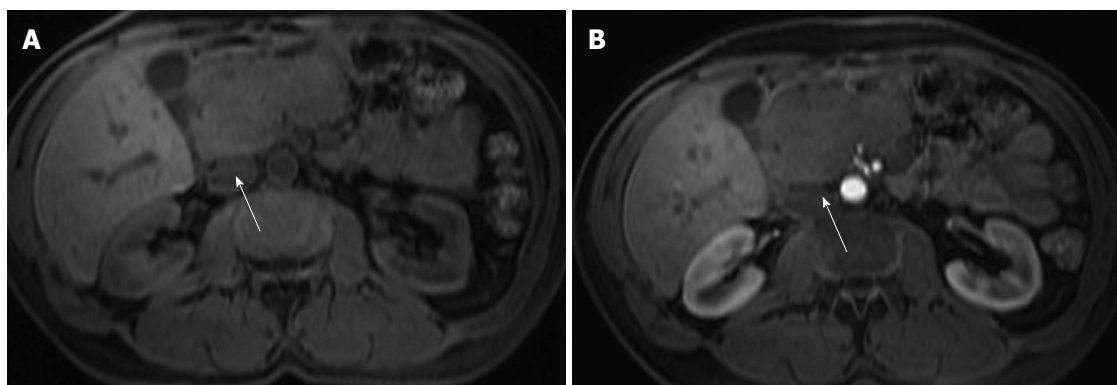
Pancreatic lymphoma. Pre-contrast fat-suppressed axial T1-weighted gradient - echo images (A) and acquired in the arterial phase after gadolinium injection (B). There is a large hypointense and hypovascular mass (arrows) localized in the pancreatic head, however showing no significant duct dilatation. There was evidence of enlarged lymph nodes. This mass was diagnosed as pancreatic lymphoma.
